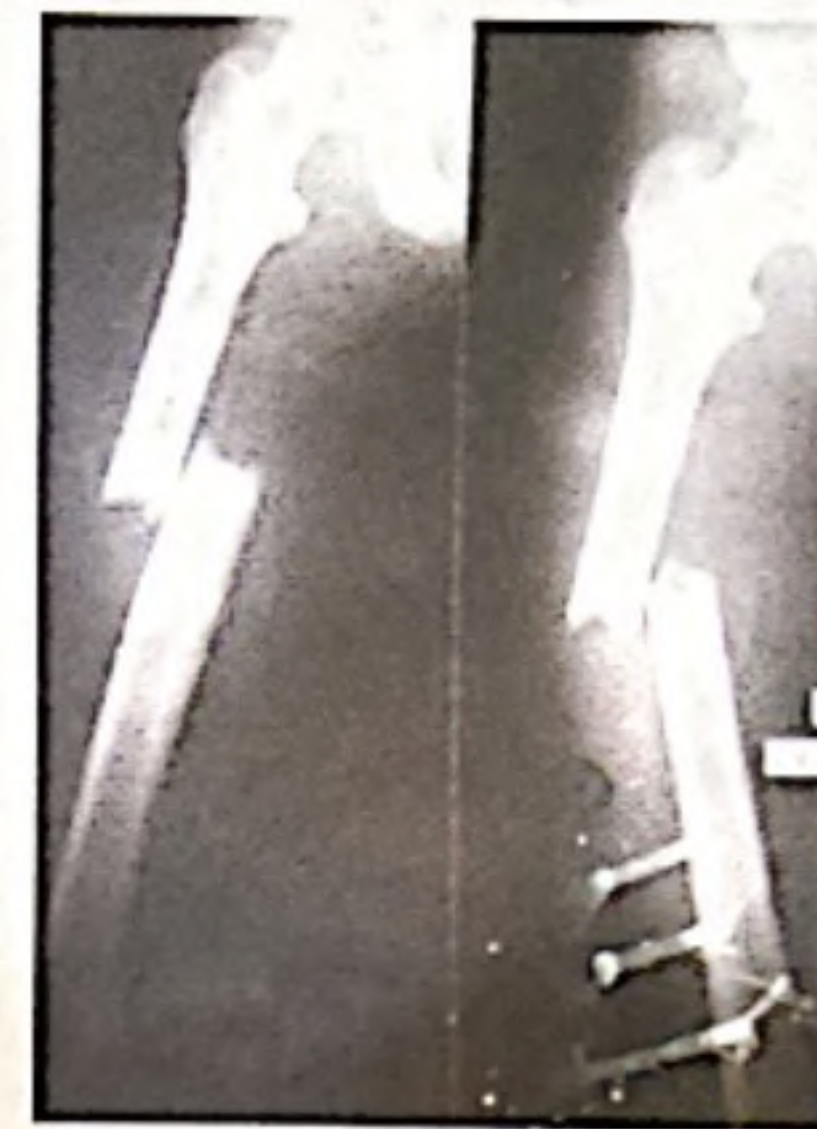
Fig no-7: Preoperative X-ray
